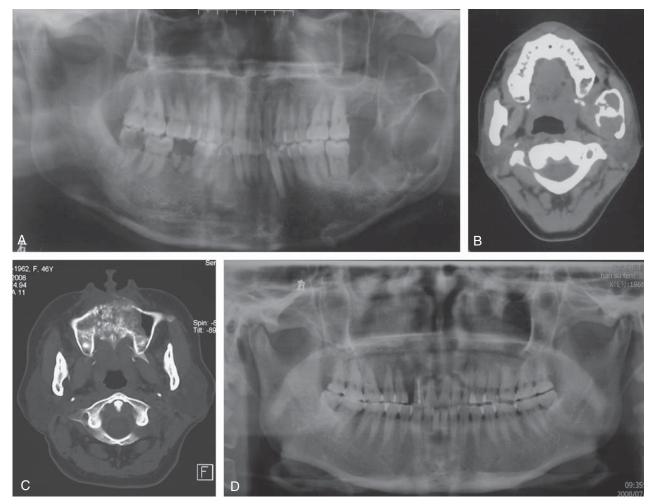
Radiographic features in central MEC. A and B, Multilocular radiolucency with relatively well-defined margin in the left mandible. C and D, Ill-defined lesion with evident bone destruction in the anterior part of the maxilla.
